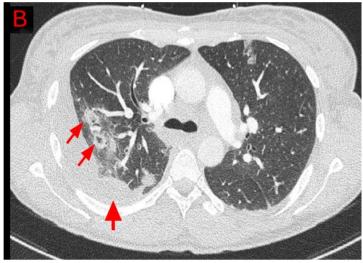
A) CTPA showing non-occlusive filling defect of the segmental branch of the left upper lobe pulmonary artery. B) CT chest showing multiple cavitary lesions and pulmonary effusions in the right lung base. C) CT neck showing thrombosis of the right internal jugular vein.
